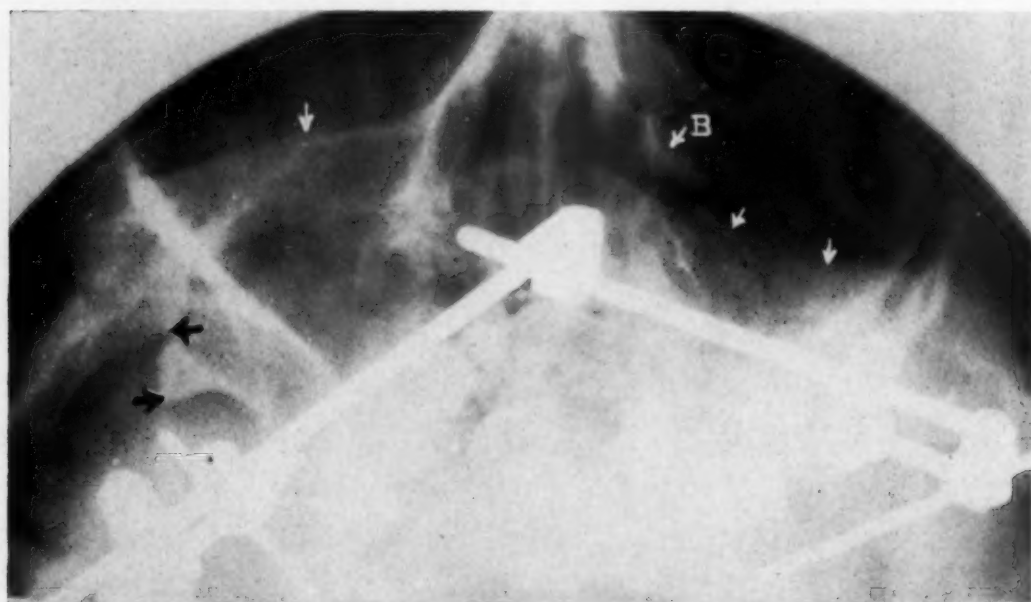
Exaggerated Water's position x-ray showing comminuted infraorbital margin on left (white arrows), and displacement of middle face skeleton backward (black arrows).
